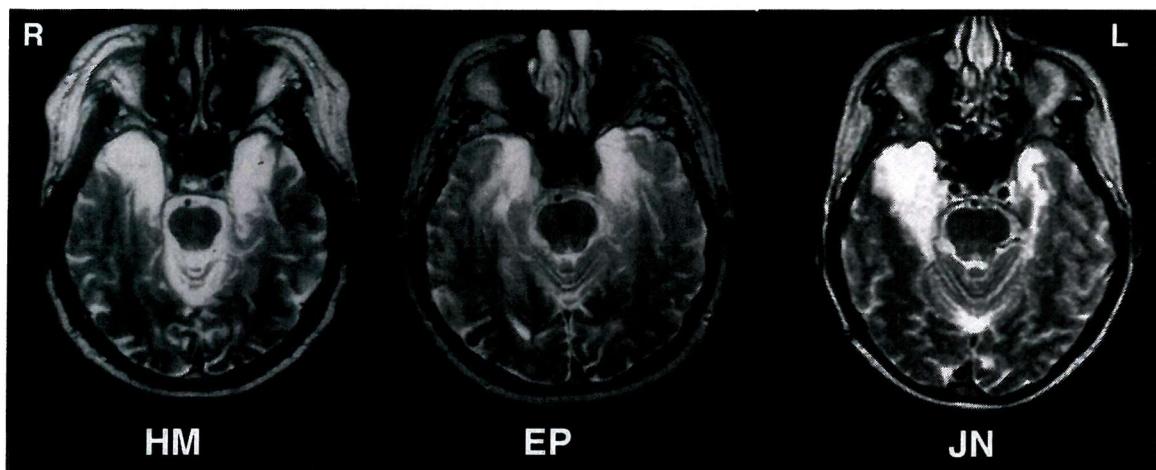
Axial MRI scans through the level of the temporal lobes of patients HM, EP and JN showing similar profiles of medial temporal lobe damage.
